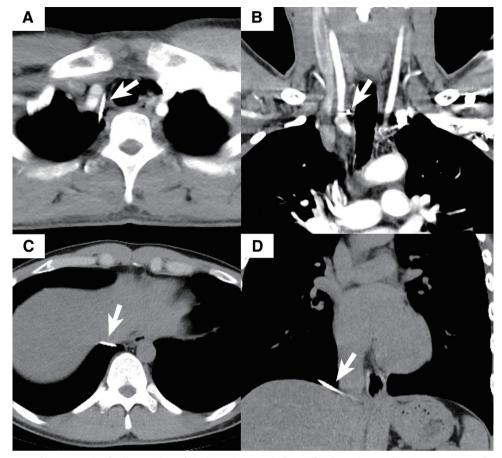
Chest computed tomography findings. The axial (A) and coronal views (B) show the needle (arrow) penetrating the mediastinum beside the brachiocephalic artery on initial imaging (C and D). The axial (C) and coronal (D) views showing the needle (arrow) on the diaphragm on follow-up imaging.
